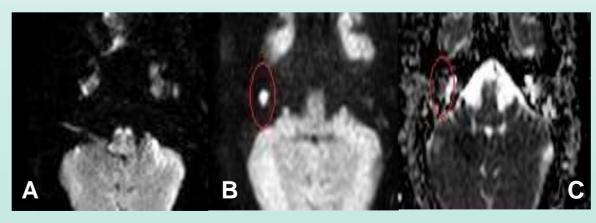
(A)Axial EPI DWI revealed no high signal of diffusion restriction with susceptibility artifact and low resolution. (B) Non- EPI revealed a high signal in right middle ear cleft (C) ADC revealed low signal denoting diffusion restriction and cholesteatoma.
